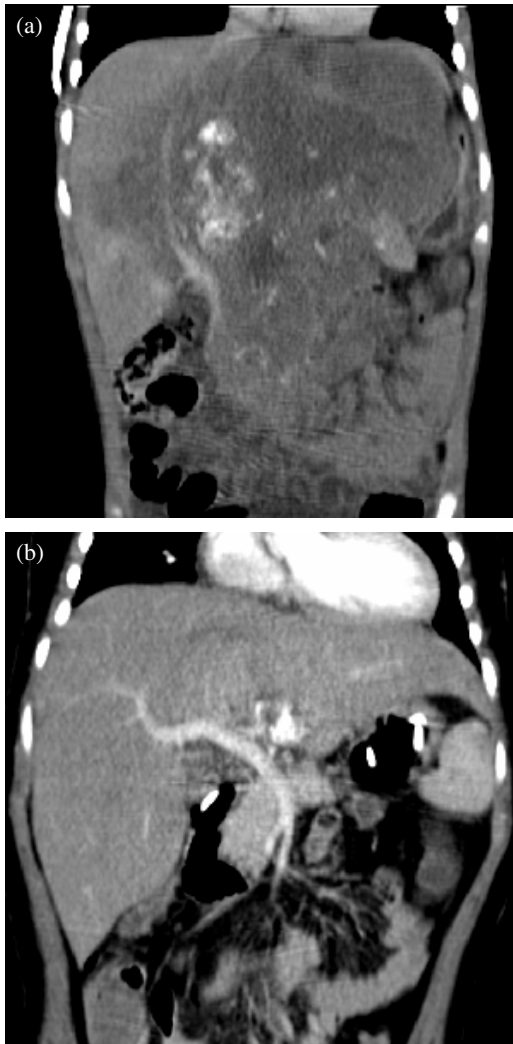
Imaging of a 2.5-year-old girl with malaise and abdominal distension. (a) Coronal CT reconstruction after injection of contrast medium shows a large heterogeneous low attenuating lesion with calcification in the right suprarenal area. It extends across the midline, and surrounds the IVC. Secondary involvement of the liver is also noted. (b) Coronal CT reconstruction in the same patient post chemotherapy, shows significant reduction in the size of the primary lesion but the portal vein remains encased (inoperable NBL).
